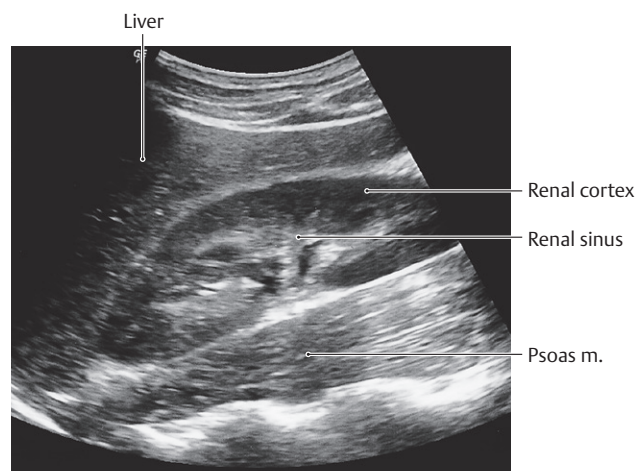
Ultrasound of the right kidney
